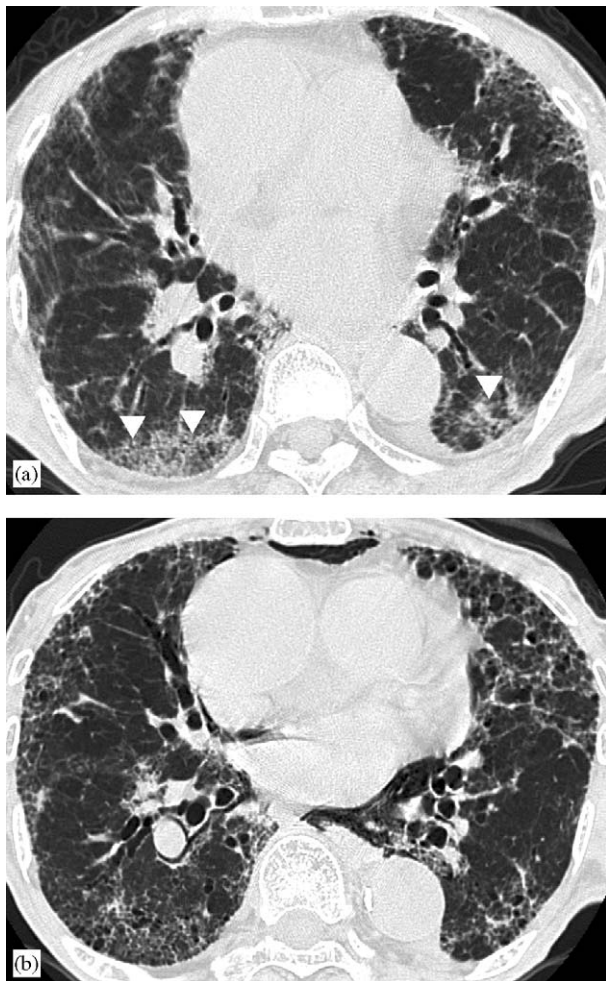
Images in 86-year-old man with exacerbation of idiopathic pulmonary fibrosis. Transverse thin-section CT shows that ground-glass opacity (white arrowhead) has been decreased at the detection of pneumomediastinum (b) as compared with before CT scan (a).
